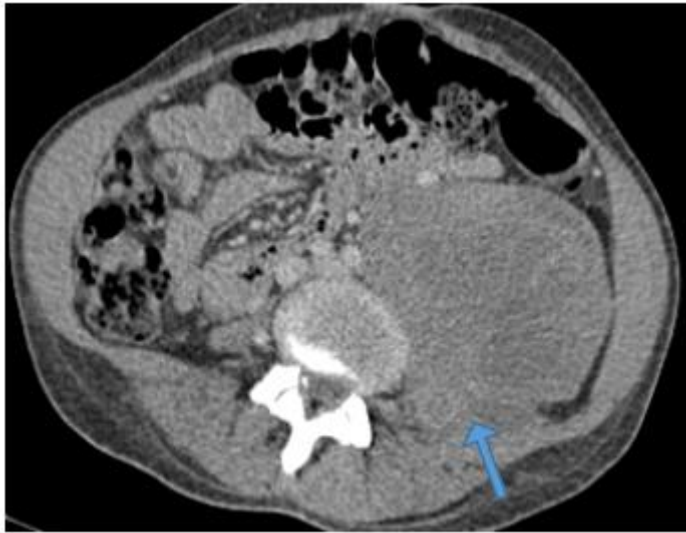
CT scan showing a retroperitoneal mass at the expense of the psoas muscle.
